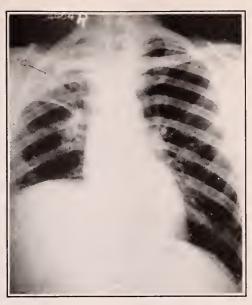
Case XII, roentgenogram of Dec. 10, 1929, showing position of diaphragm after phrenicectomy on the right. Much of the exudative type of density has disappeared, cavity has decreased noticeably in size (c).
